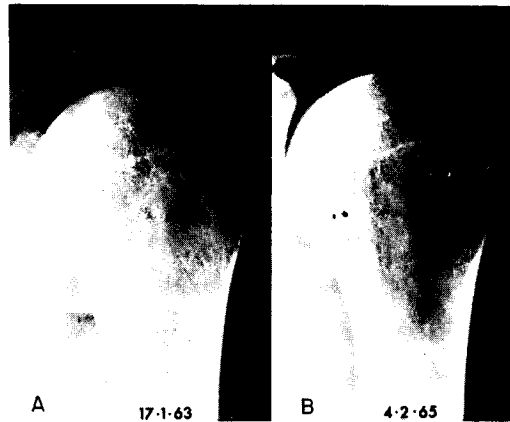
A. Ill-defined dense areas in the head of the left humerus representing early radiographic evidence of osteonecrosis. Patient had worked in compressed air for 17 months at pressures up to 37 p.s.i.g. and never had type I or type II bends (see B).
